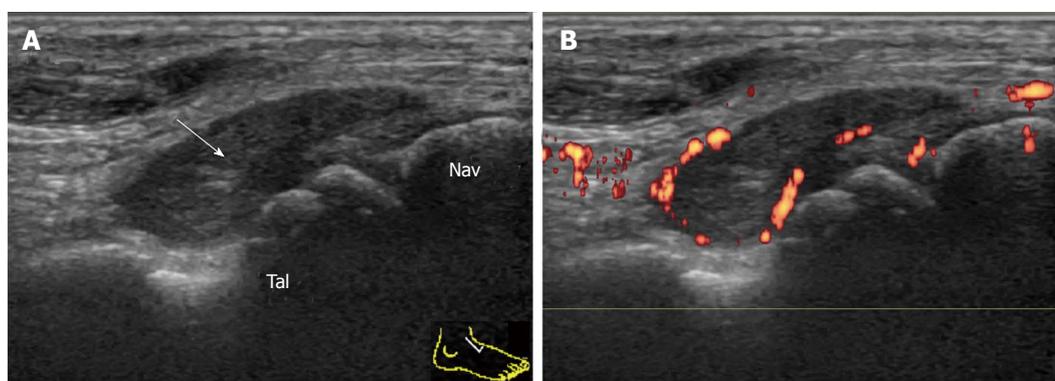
Synovitis of the talonavicular joint in rheumatoid arthritis. Longitudinal grey-scale (A) and power Doppler (B) sonogram of the dorsal aspect of the TNJ shows marked synovial thickening (arrow) with peripheral vascularization. Tal: Talus; Nav: Navicular; TNJ: Talonavicular joint.
